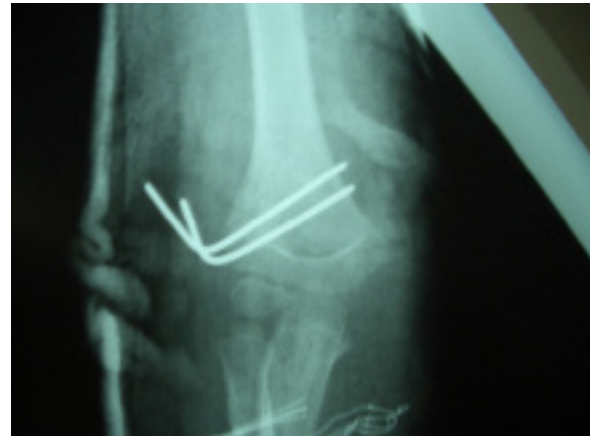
Postoperative AP X-ray. Supracondylar fracture of the humerus (Gartland type II) laterally approached with 2 K-wires.
